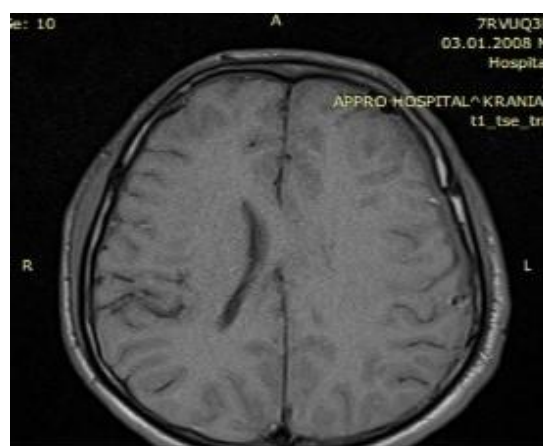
Axial section MRI of left sided epidural abscess
